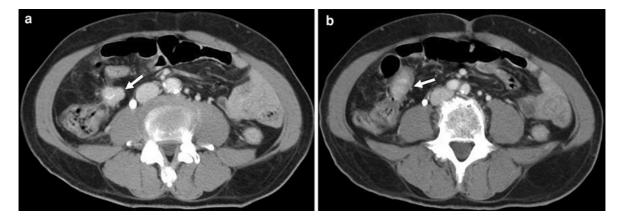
Axial multidetector-row CT images of a patient with a carcinoid tumor of the terminal ileum (*arrow in b*), showing a mesenteric soft-tissue mass with radiating septa and small calcifications (*arrow in a*)
